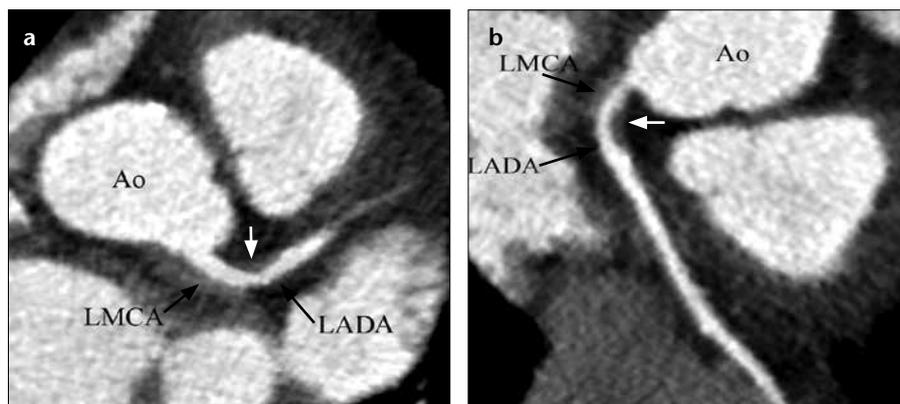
a, b. A 67-year-old woman presented with angina pectoris and two risk factors, which are diabetes mellitus and hypertension. Axial (a) and curved planar reformatted (b) CT angiography images reveal a noncalcified soft plaque (white arrows), causing a nonsignificant (<50%) stenosis in the LMCA and the proximal segment of the LAD artery (Ao, aorta; LADA, left anterior descending artery; LMCA, left main coronary artery).
